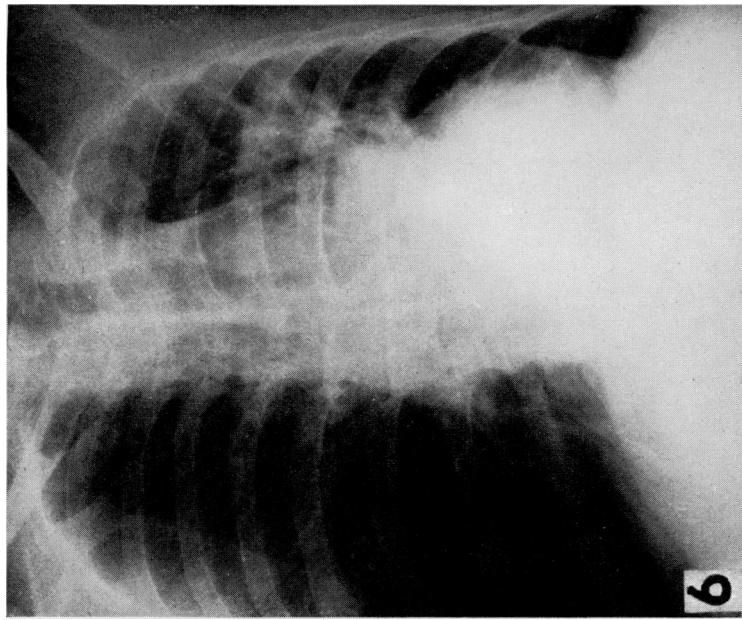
Roentgenogram of chest of a patient with bronchiectasis of the left lung, made in January 1949. Fibrosis is demonstrated in the left lower lobe, but there is also much radiolucent tissue especially in the left lower lobe, despite the universal bronchiectasis of all segments (Figs. 8 and 9).
